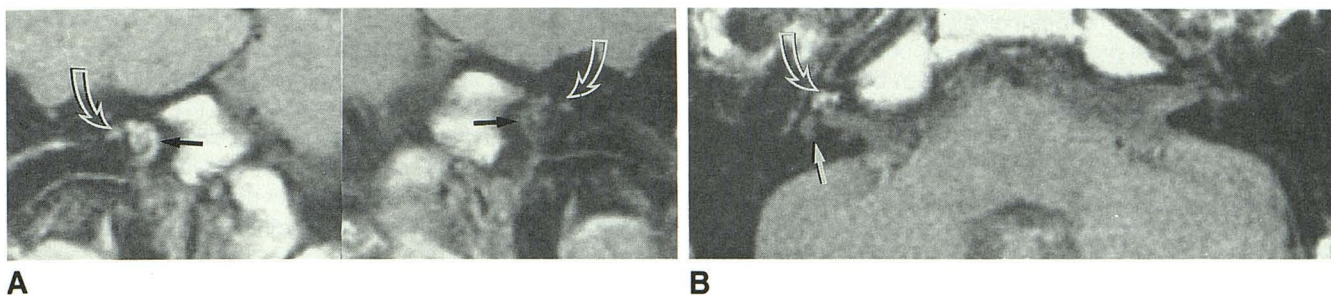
Case 3: T1-weighted enhanced images, 600/20/4, in patient with profound right-sided hearing loss, facial palsy on the right, moderate left-sided hearing loss, and positive CSF and blood serology for syphilis.
